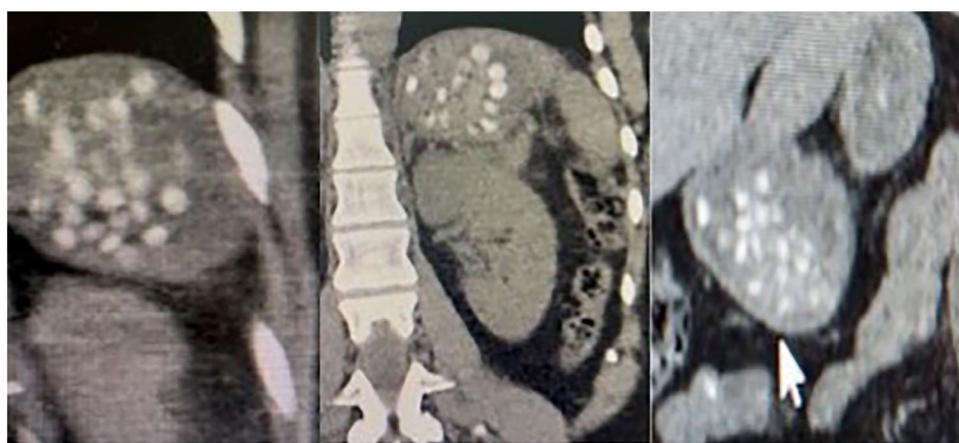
Computed tomography of the abdomen in the three patients where it was performed within 6 h of overdose.
